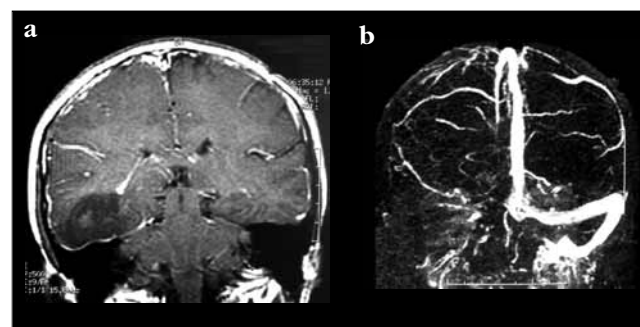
(a) T1-weighted brain MRI with contrast medium administration showed a right temporal cortico-subcortical hypointensity. (b) Magnetic resonance venography indicated the blocked venous flow of the right transverse and sigmoid sinuses
